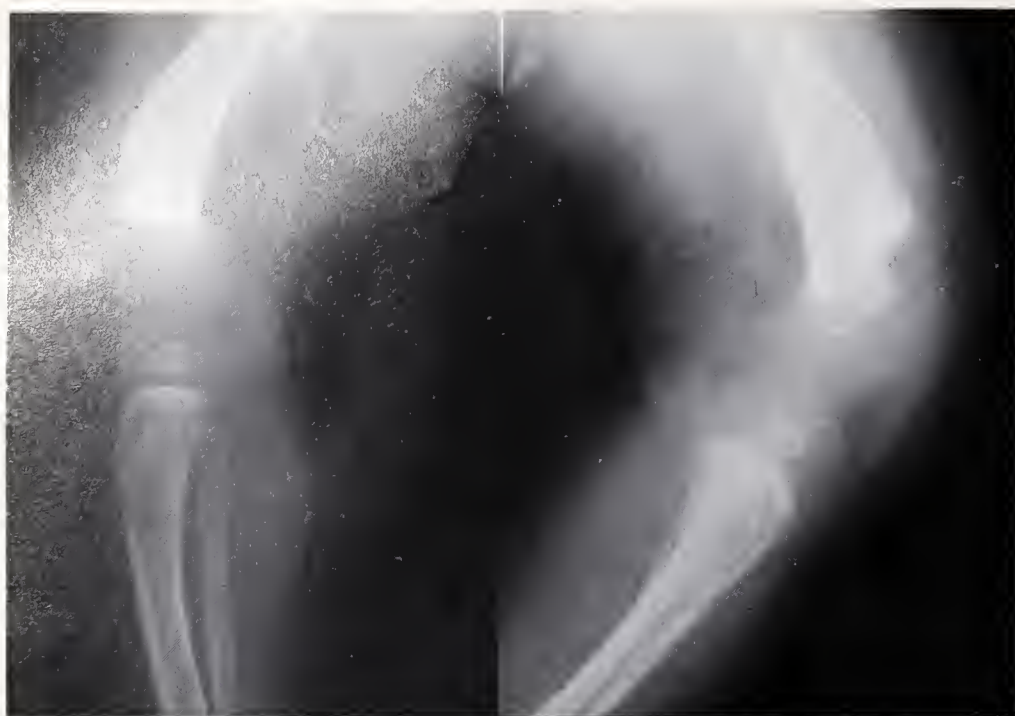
Radiographs four months later with healing fractures and early remodeling.
